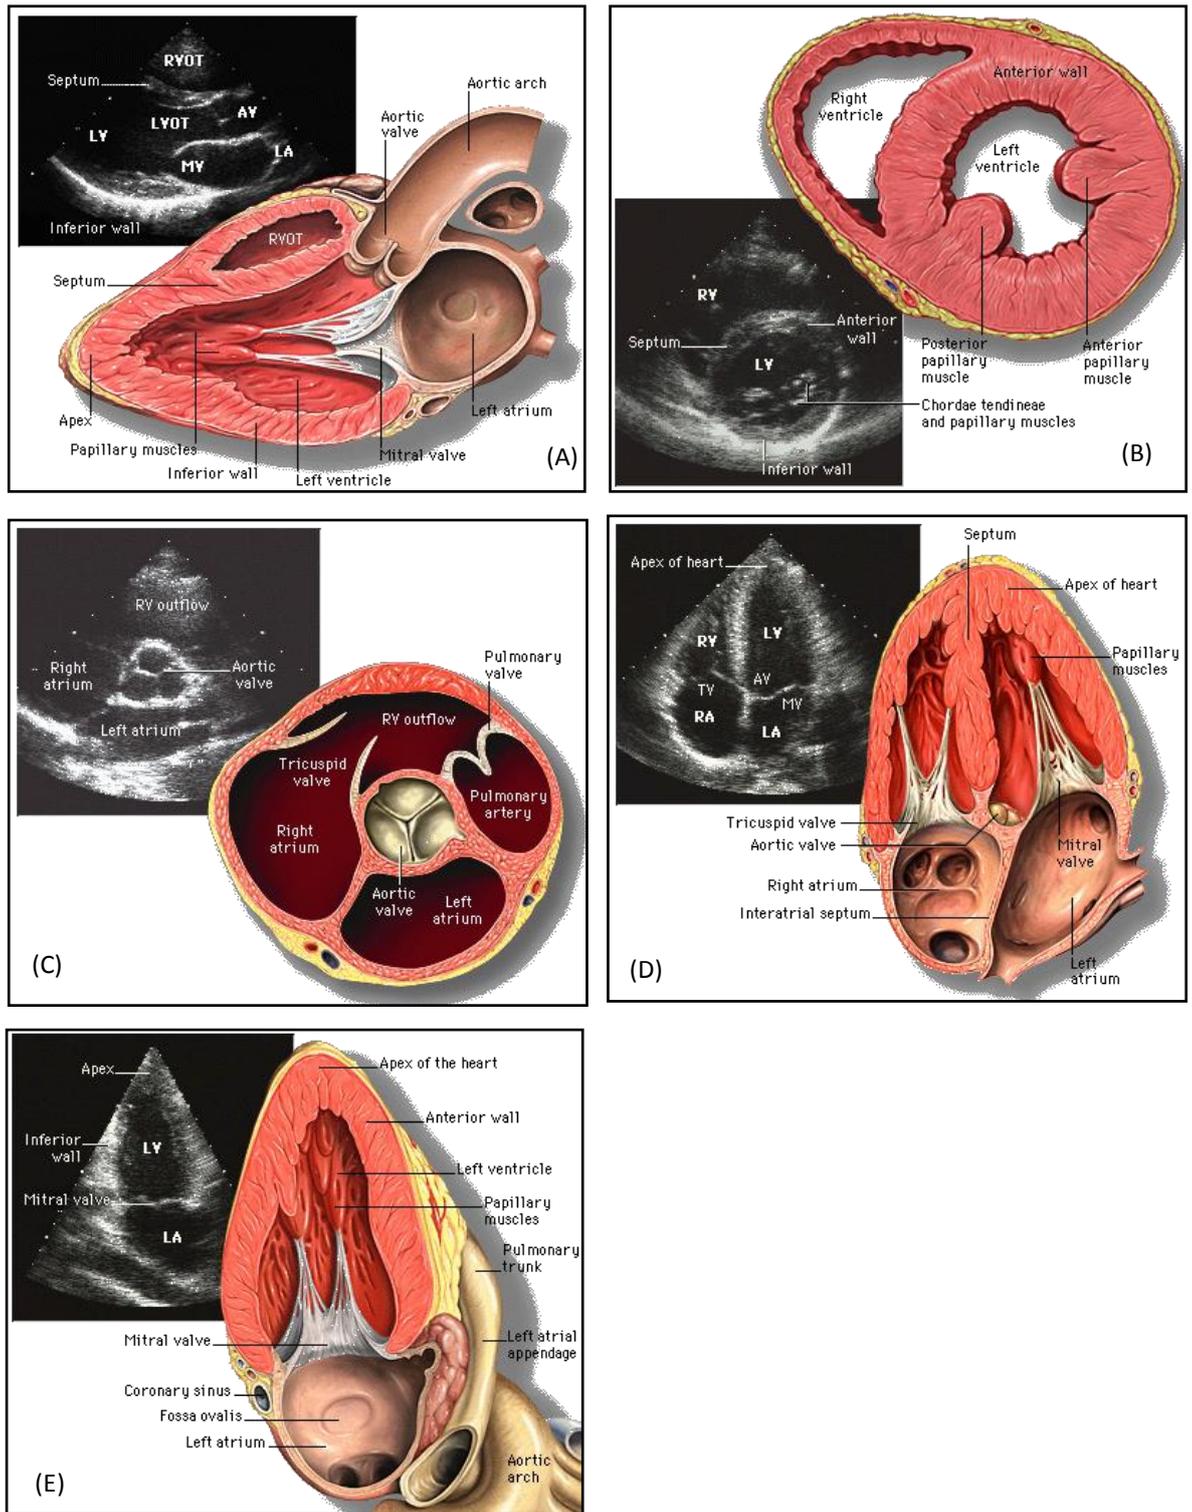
Transthoracic echo images: (A) Left parasternal long axis view ; (B) Parasternal short axis view, mitral valve level, (C) Parasternal short axis view, aortic valve level, (D) Apical four chamber view, (E) Apical two chamber view. (RVOT: right ventricle outflow tract, LVOT: left ventricle outflow tract, RA: right atrium, LA: left atrium, RV, right ventricle, LV: left ventricle, TV: tricuspid valve, AV: aortic valve, MV, mitral valve) (Vannan *et al.*, 2006).
